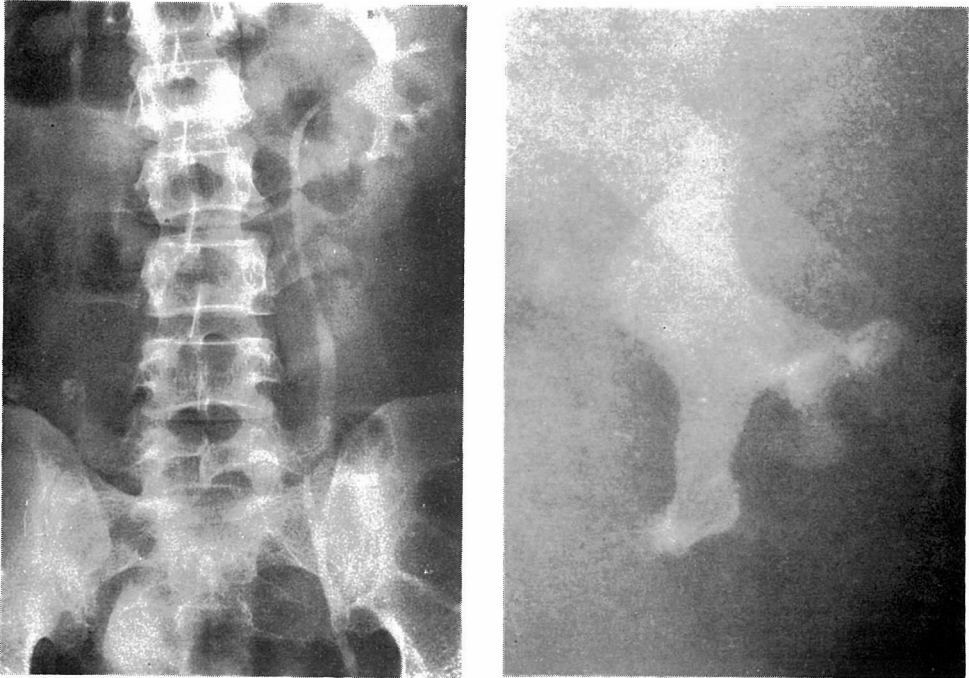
A plain film of the abdomen (right) and an intravenous urogram (left) showing a less radiopaque coral stone in the remaining left kidney.
